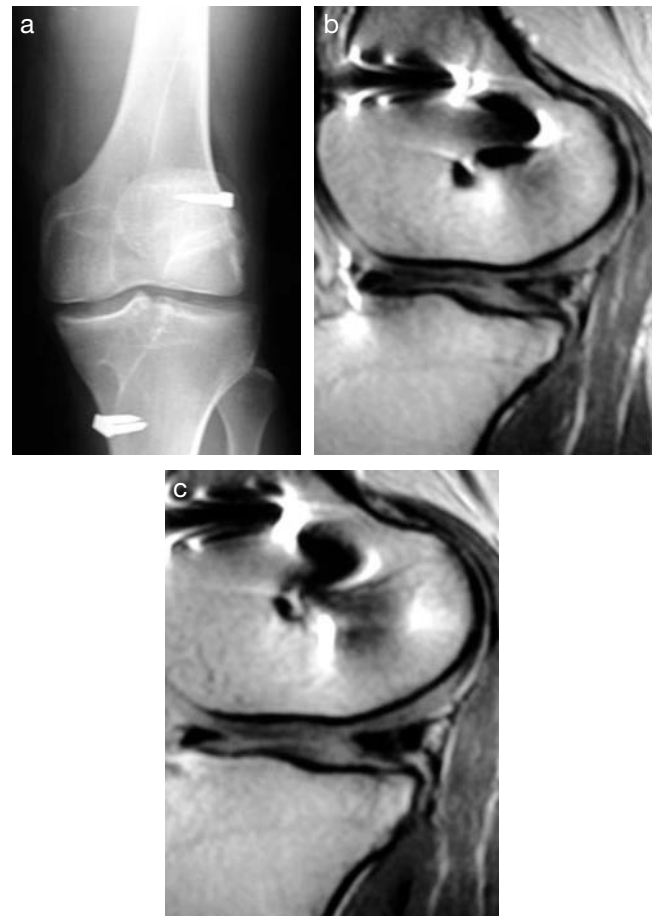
Collagen meniscal implants (CMIs) showing a satisfactory clinical evolution at 2 years. a: weightbearing x-ray. b and c: MRI showing a CMI that preserves the joint space.
